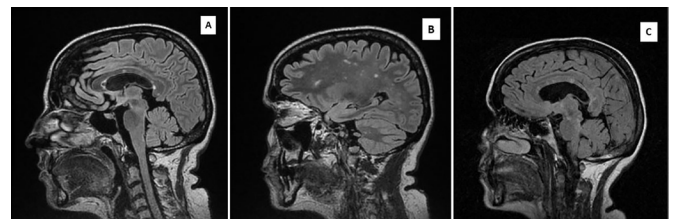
Fluid-attenuated inversion recovery sagittal MRI 1 month later at second (A,B) and third (C) hospitalisations. (A) The remaining lesions still including the characteristic lesions of the corpus callosum, although to a lesser extent than those shown on the first MRI. (B) Diffuse subcortical white and grey matter lesions. (C) New subcortical and pons and medulla oblongata junction T2 hyperintense lesions.
